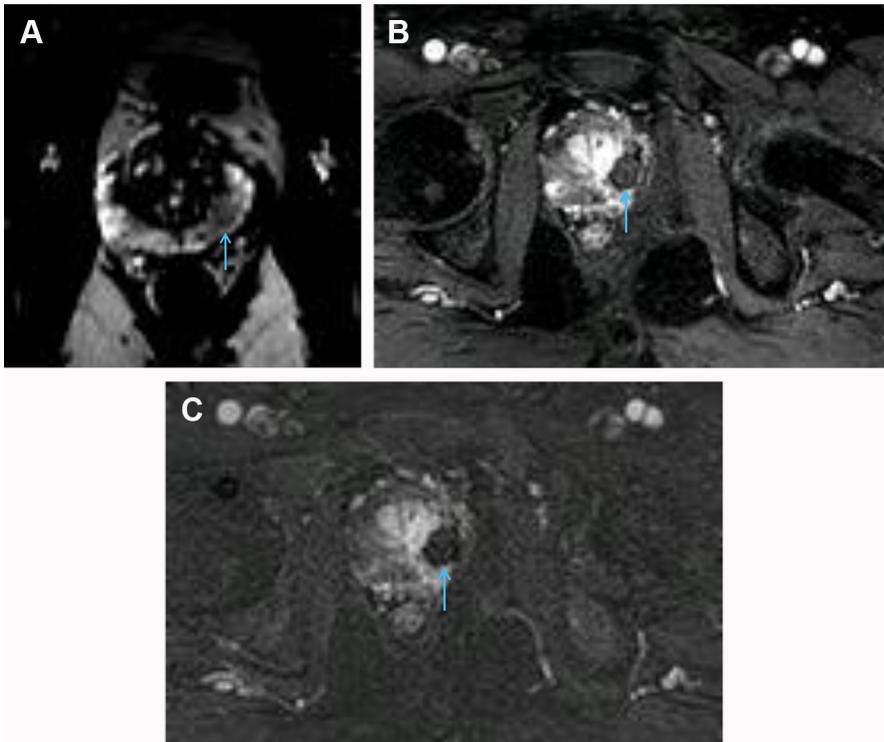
Focal laser ablation. A 60-year-old patient with Gleason 7 prostate cancer underwent focal laser ablation for a lesion located in the left apex (arrows). Prophylactic antibiotics were administered to the patient prior to and after the procedure. Treatment was done using moderate-degree conscious sedation. A laser ablation template was placed on the patient's perineal surface and a lesion on MR imaging suspicious for prostate cancer was successfully localized. After the administration of lidocaine for local anesthetic, MR-compatible needles were directed into the area of the aforementioned lesion. After confirmation of needle location, ablation was performed. (A) A T2 hypointense cancerous focus is seen in the peripheral zone of the left apex. (B, C) After localized laser ablation, regional hypoenhancement is apparent in the left apex/midgland on unsubtracted and subtracted postcontrast imaging sequences, respectively.
